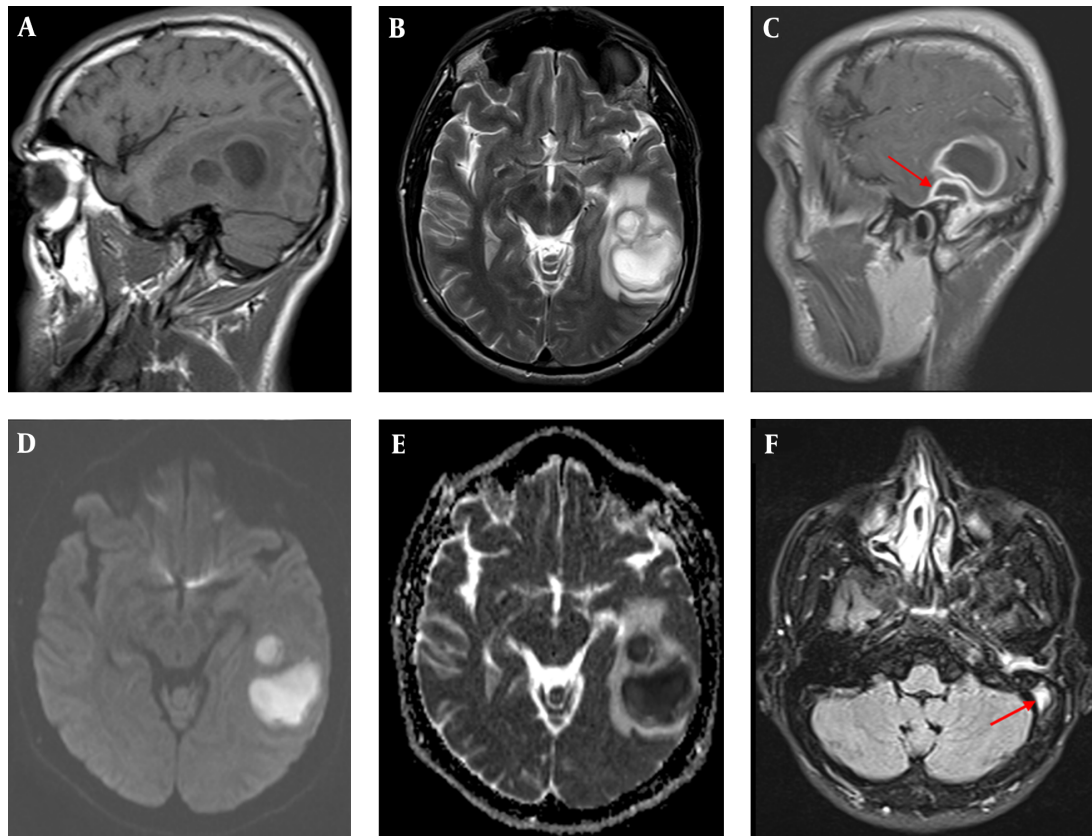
Contrast-Enhanced Cranial Magnetic Resonance Imaging. (A) the Sagittal T1-Weighted Image Showing Two Adjacent Circular Hypo-Intense Lesions and Their Mild T1 Hyper-Intense Walls At Left Temporal Lobe; (B) the Axial T2A Image Indicating the Walls of the Lesions Are Mildly Hypotensive and Surrounded by Vasogenic Edema; (C) Contrast-Enhanced Sagittal T1A Image Showing Smooth Thick Contrast at the Walls of the Lesions Which Is Accompanied By Epidural Abscess (Arrow) in the Floor of the Left Temporal Lobe, Adjacent to Intra-Parenchymal Lesions; (D,E) Diffusion-Weight Imaging Demonstrating Limitation of Homogenous Diffusion, Typical for Abscess, at the Central to the Left Temporal Lesions; (F) the Axial FLAIR Image Monitoring the Intraluminal Hyper Intensity of the Left Sigmoidal Sinuses, on Behalf of Thrombosis.
